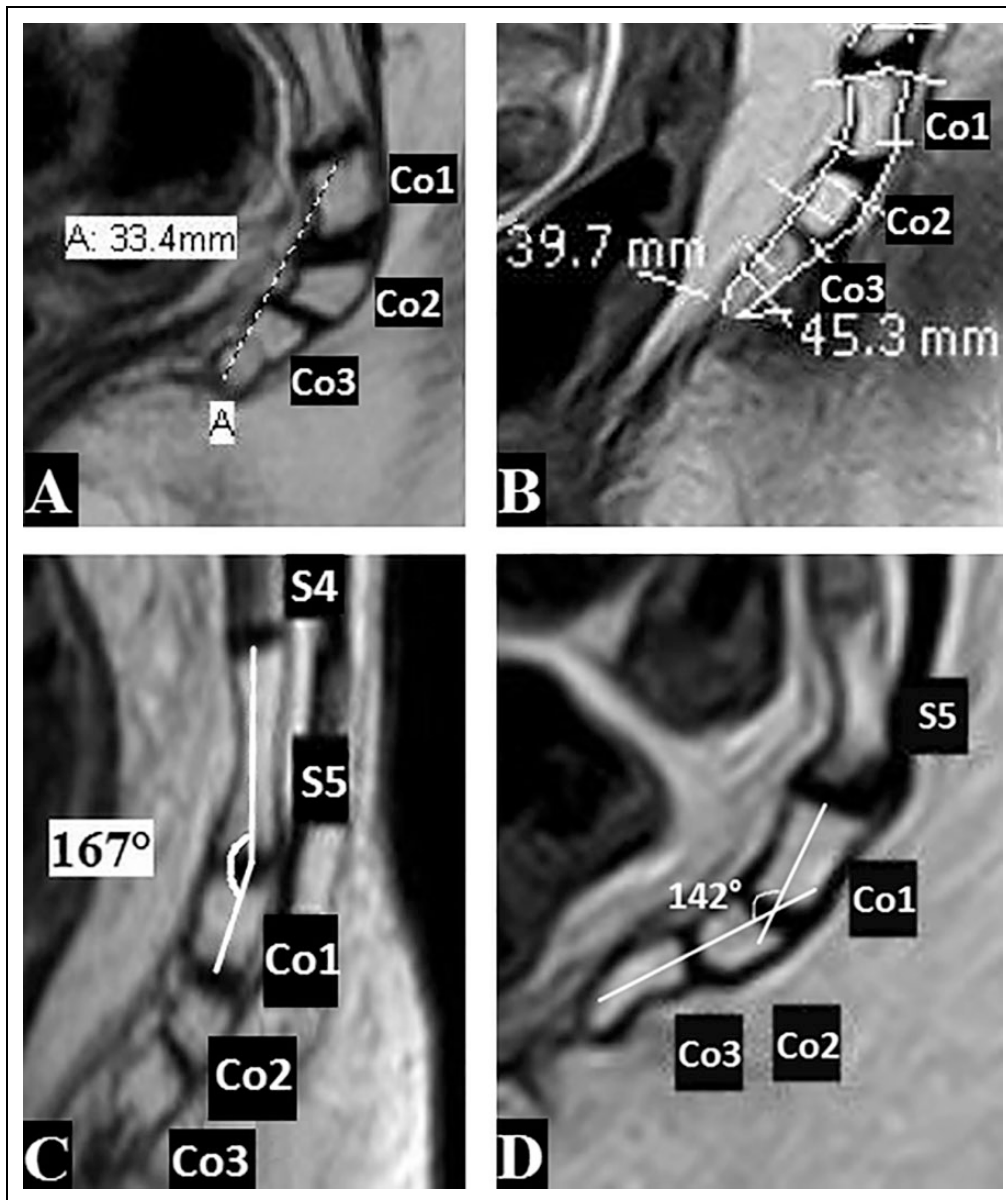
MRI of the sacrococcygeal region showing: (A) Coccygeal straight length: Length of a straight line from the middle of the upper border of Co1 to the coccygeal tip. (B) Coccygeal curved length: Average of the anterior and posterior curved coccygeal lengths measured from the upper border of Co1 to the coccygeal tip. (C) Sacrococcygeal joint angle: Angle between lines intersecting the middle of S5 and Co1. (D) Intercoccygeal angle: Angle between lines intersecting the middle of the Co1 and last coccygeal segment.
